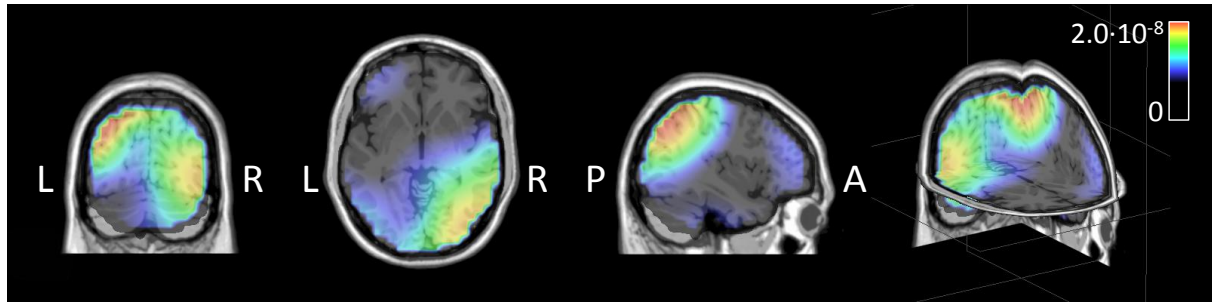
Example swLORETA inverse solution data. From left to right a coronal, axial and sagittal slice are shown together with an orientation of these slices in 3D space. Inverse solution data is modeled by 5902 dipoles of varying magnitude at 7 mm resolution and depicted by a color map onto a standard MRI dataset. The values are standardized and unitless. Abbreviations are: L=left, R=right, P=posterior and A=anterior. Two hotspots are visible in the posterior area of the brain both left and right.
